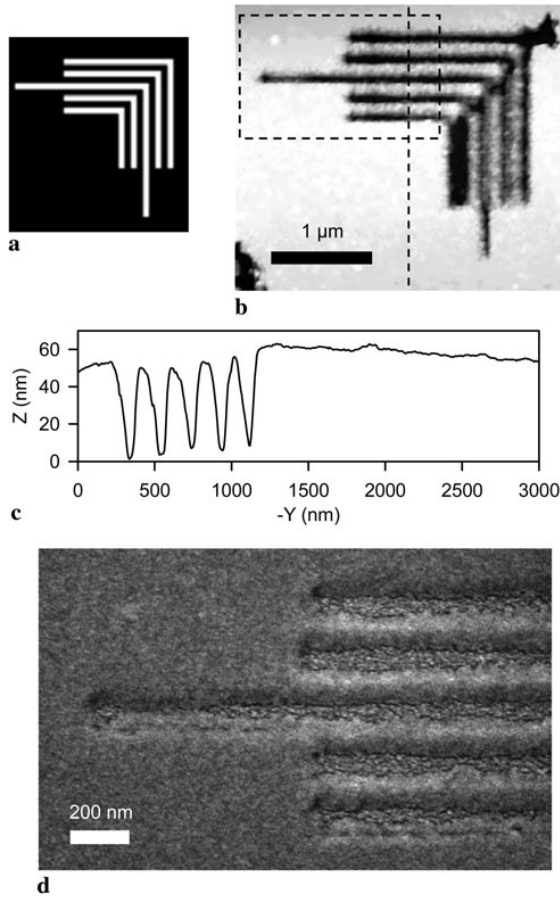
(a) The elbow pattern used to drive the sample positioning stages relative to the focal point. (b) AFM image of the pattern directly written in PMMA with focused 300 eV monochromatic X-rays after development. Dose: 1 MGy. (c) Line out from the *dashed vertical line* in (b). (d) SEM image of the region outlined by the *dashed rectangle* in (b) demonstrating 40 ± 5 nm 1:2 developed lines
